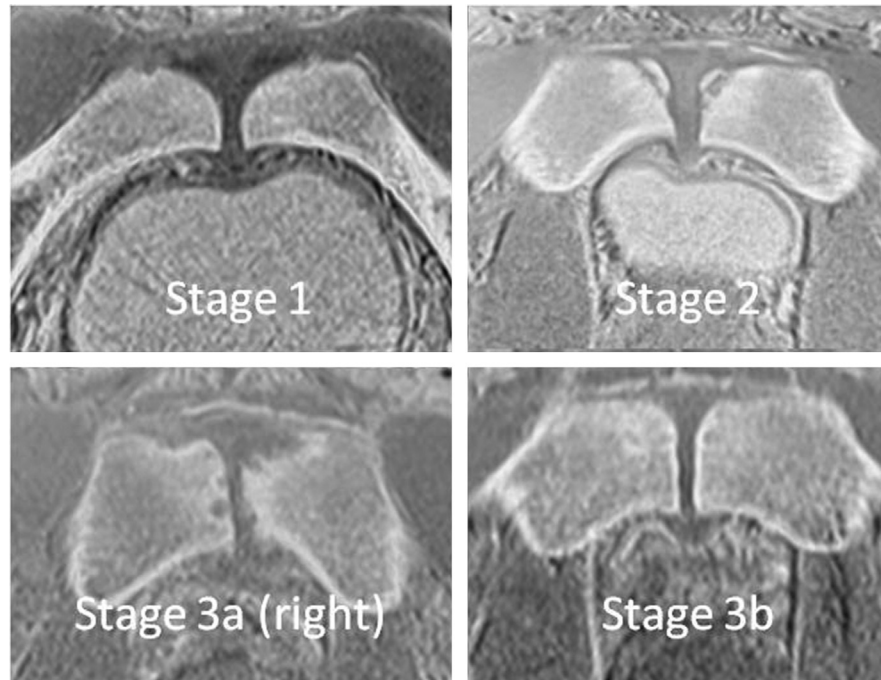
Axial inverted VIBE MRI of the superior pubic symphysis. Staging of superior and inferior pubic symphysis maturation was performed as per the study of Saily *et al.* Stage 1 shows absence of the secondary ossification centre on the left. Note the right apophysis shows very early ossification (Stage 2). Stage 2 shows development of a secondary ossification centre with delayed maturation and apophysiolytic changes on the left. Stage 3a shows an incompletely ossified right superior apophysis anteriorly. Left apophysis shows delayed maturation with apophysiolytic changes giving the appearance of erosions. Stage 3b maturation shows fully formed ventral pubic bones.
